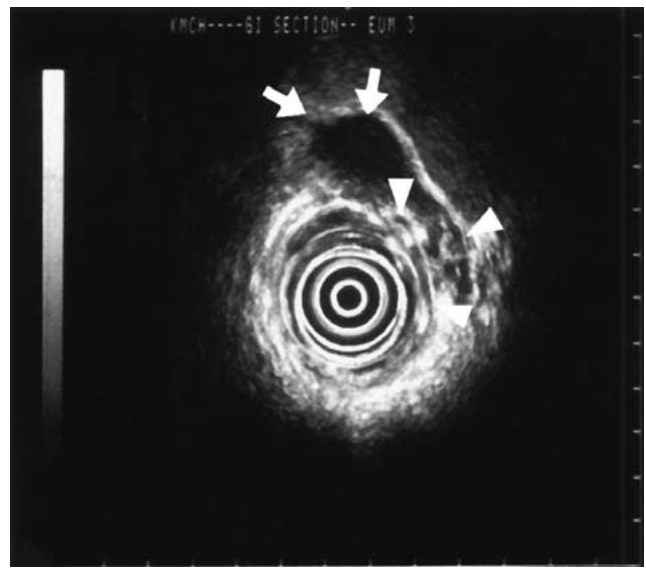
Endoscopic ultrasonography (EUS) showing grade 2 fundic-type gastric varices (GV) (arrowheads) connecting to grade 2 para-gastric veins (PGV) (arrows).
